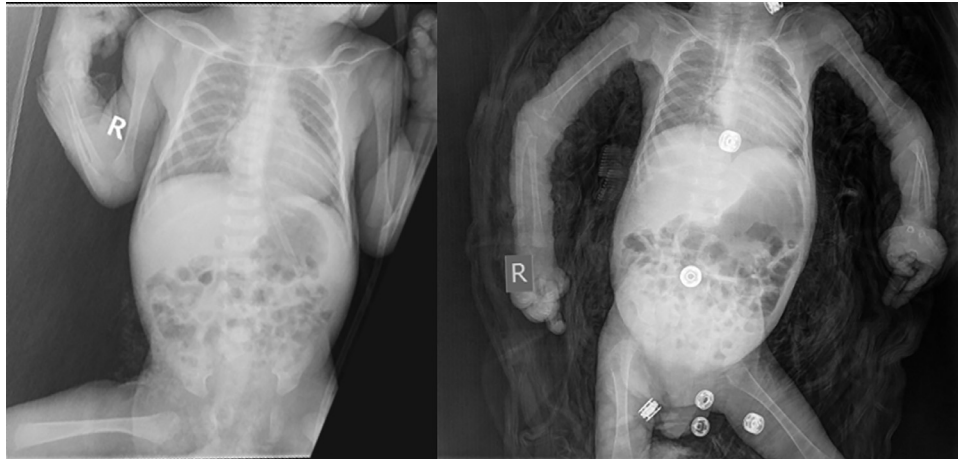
Chest radiograph demonstrating an abnormal cardiac silhouette, a narrow, bell-shaped thorax, and thin, under-mineralized bones in a 7-month-old patient with significant growth restriction.
